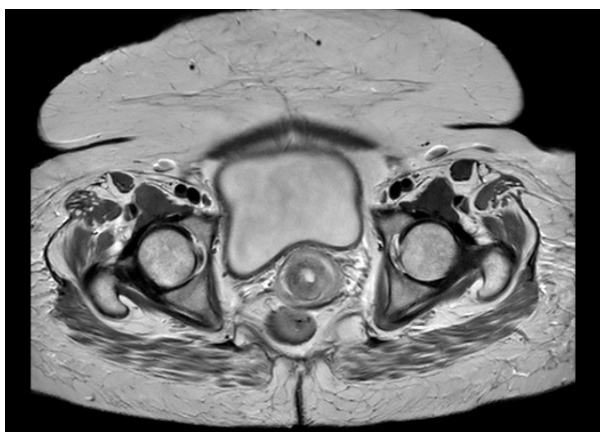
Axial T2-weighted MRI showing altered uterine morphology with inferiorly inverted uterine fundus and intact cervix, suggestive of uterine inversion
